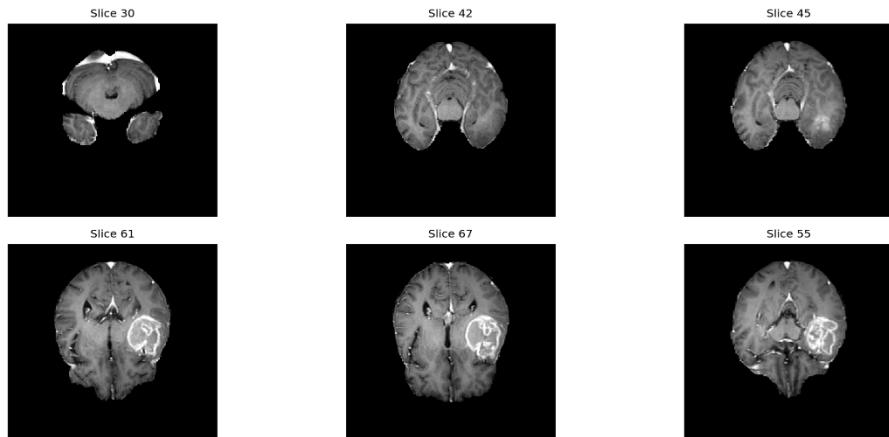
Example of contrast -enhanced T1-weighted MRI slices from the BraTS 2023 dataset, with different cross-sections of the brain.
